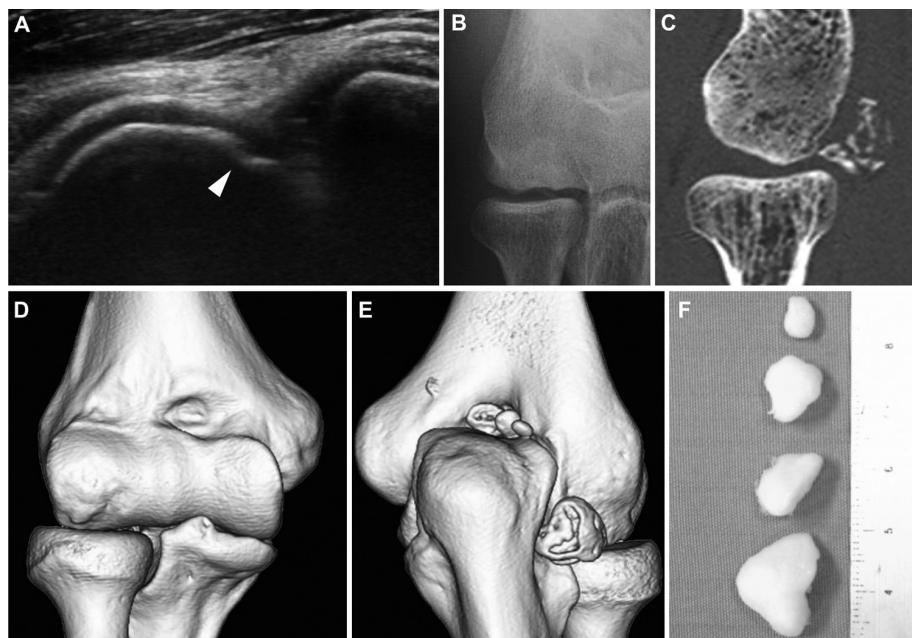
Stage III (loose body stage) osteochondritis dissecans of the humeral capitellum (loose bodies and sclerotic change). (A) Ultrasonographic image obtained during the initial screening (anterior long-axis view). Irregularity of the subchondral bone was observed on the capitellum. (B) Radiograph (45° flexed tangential anteroposterior view) obtained at the initial examination. (C) Sagittal slice of the capitellum by computed tomography. (D) Anterior view of the 3-dimensional computed tomography. (E) Posterior view of the 3-dimensional computed tomography. (F) Loose bodies that were removed by arthroscopic surgery.
